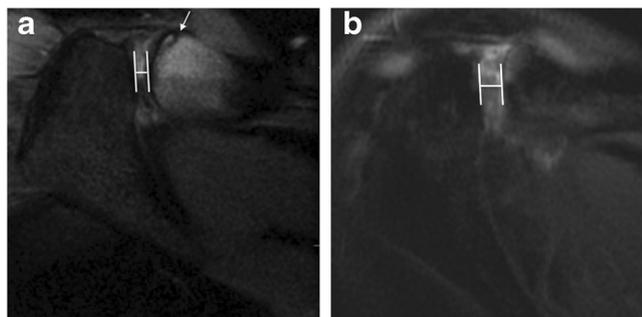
Interval widening of the acromioclavicular (AC) joint on follow-up imaging of a patient with distal clavicular osteolysis (DCO). Two axial PD FS images through the AC joint were performed on the same patient. a An 18-year-old female short-distance freestyle swimmer participating in a weight-training program twice a week presented with grade II DCO (with a small subchondral fracture, arrow) and an AC width of 3.3 mm. b The same patient (as in a) presented 4 years 9 months later with AC joint pain. MR imaging revealed flattening of the distal clavicle, widening of the AC joint now to 6.7 mm (interval widening: 3.4 mm), and early (grade I) osteoarthritis with small marginal osteophytes at the AC joint
